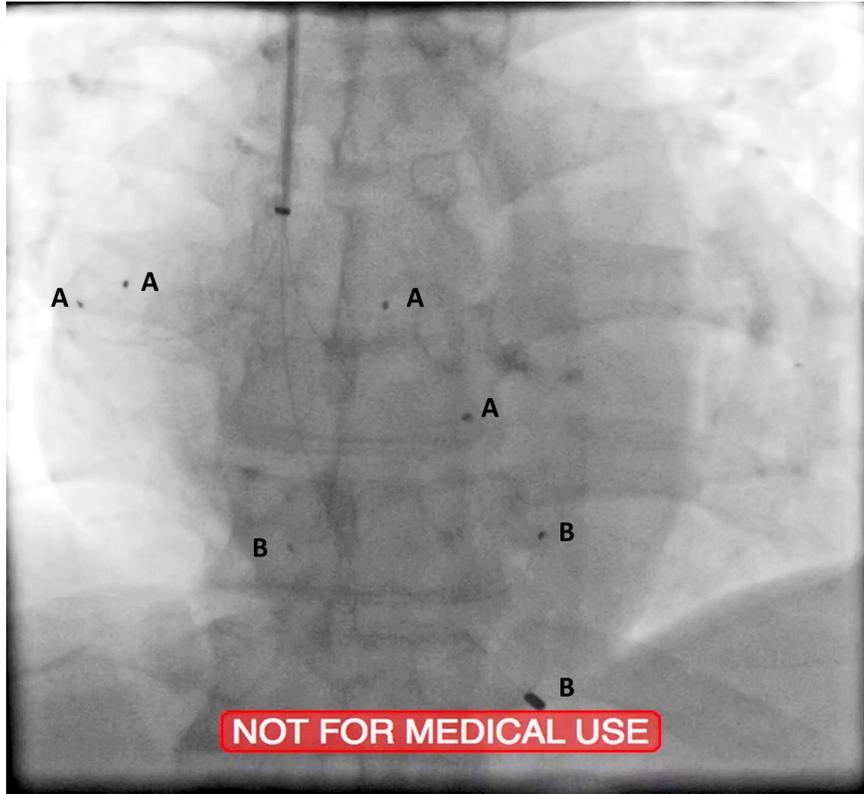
X-Ray of AVPS Atrial leads (A) in the RA and Ventricular leads (B) in RV
